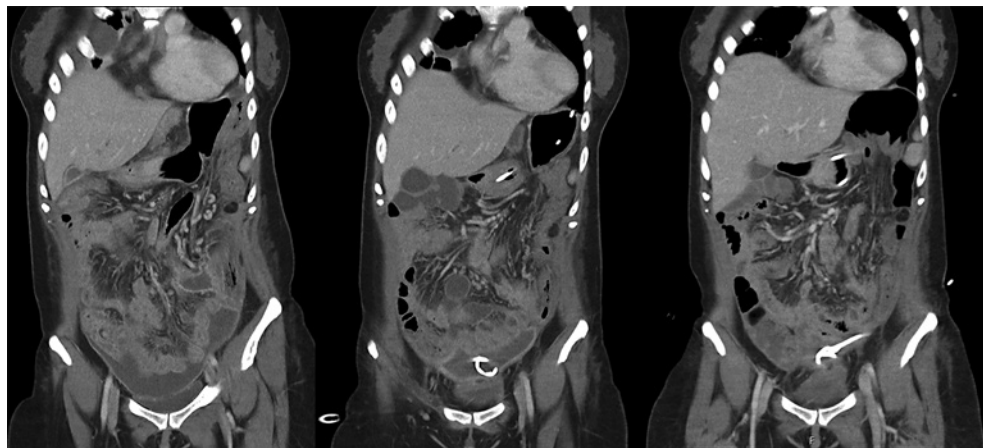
CT scans of the fluid collections in the pelvis, which are taken on various moments during admission. The CT scans were made on days 6, 17, and 24 of admission. The fluid collections were fully drained on day 24.
